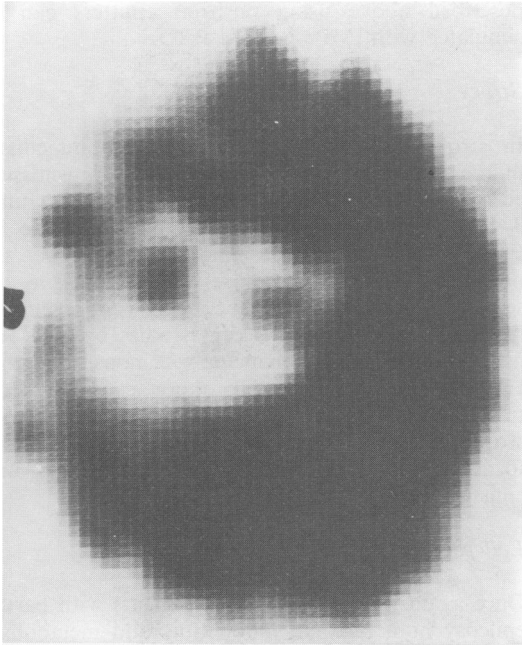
SPECT image using technetium-99m HM-PAO of a section through the brain of an 8 year old girl with partial seizure disorder, showing a photon-deficient area in the right frontal area.
